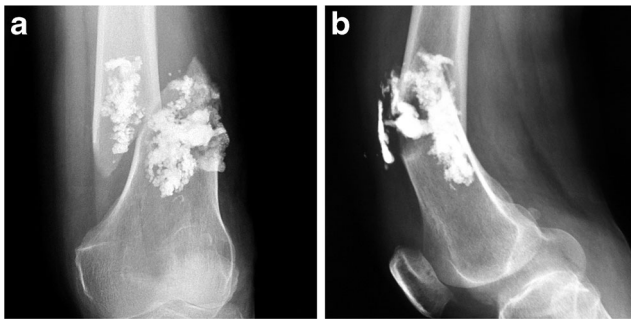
The same patient as in Fig. 1. (A, B) A pathological fracture is depicted at the treated site in the right distal femur on the frontal and lateral radiograph at the 1-month follow-up
